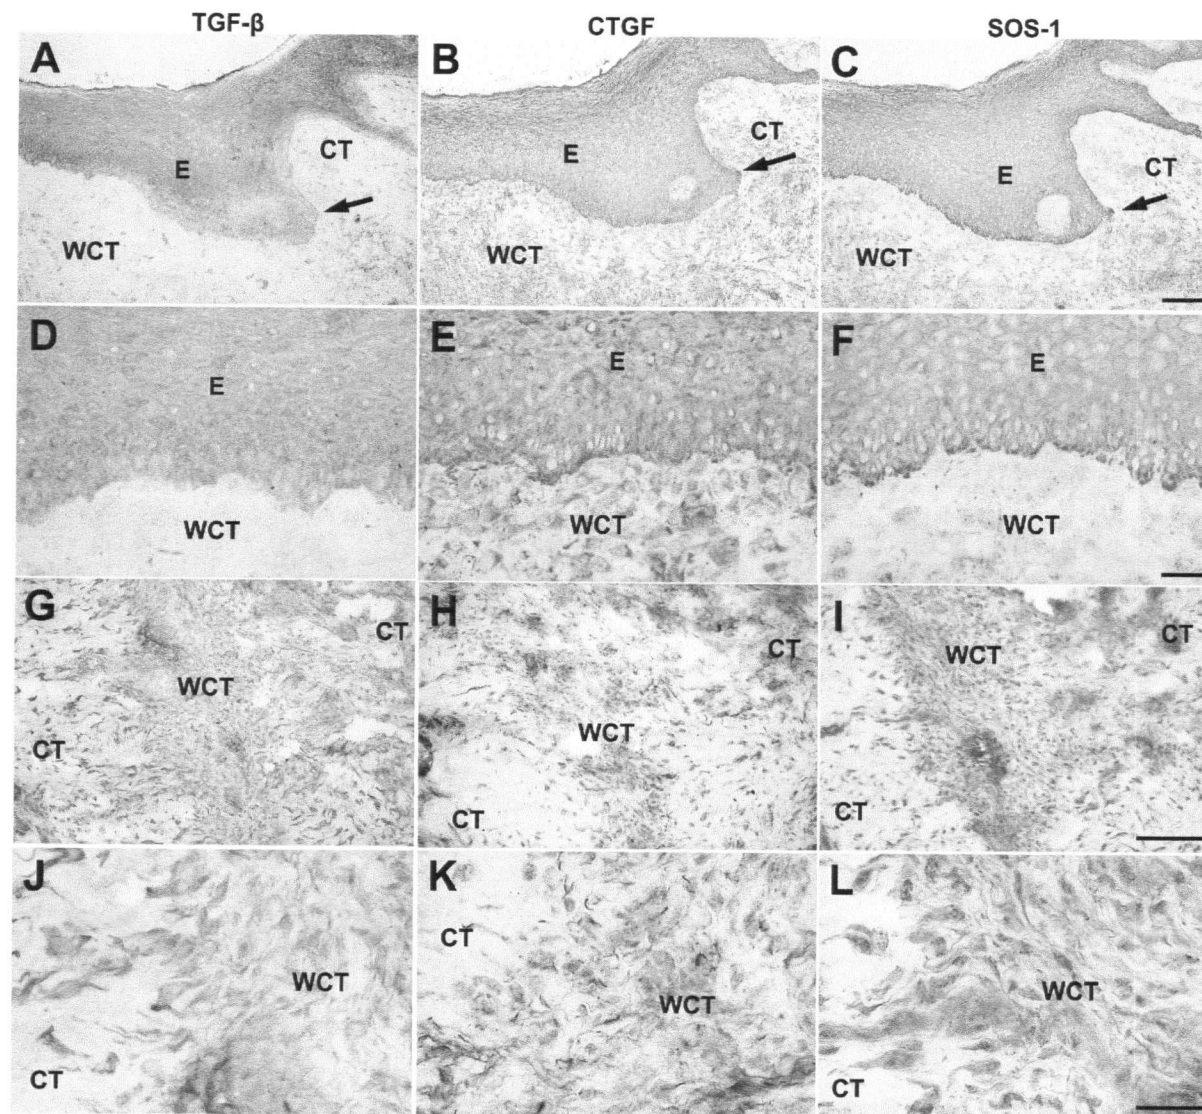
Expression pattern of TGF- β (A, D, G and J), CTGF (B, E, H and K) and SOS-1 (C, F, I and L) in palatal attached gingiva 14 days post wounding. A-C: Arrows indicate the wound edge. E = epithelium; CT = connective tissue; WCT = wound connective tissue. Bar 100 μ m
